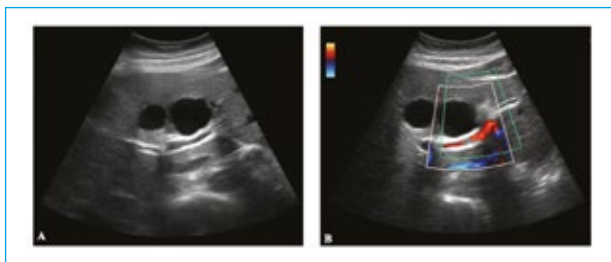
B-Mode ultrasound (A) and Color-Doppler images (B) obtained using a multi-frequency (2.5–5 MHz) convex probe shows two the presence of two centimetric, contiguous, intrahepatic bilomas.
